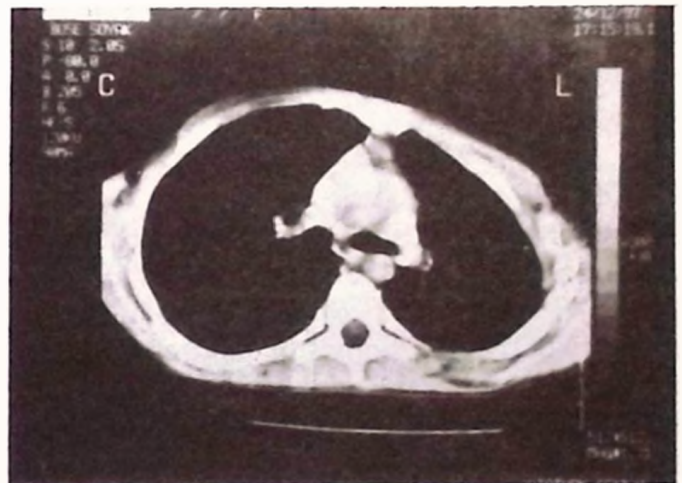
Chest computed tomography showing only minimal pleural thickening on the left.
